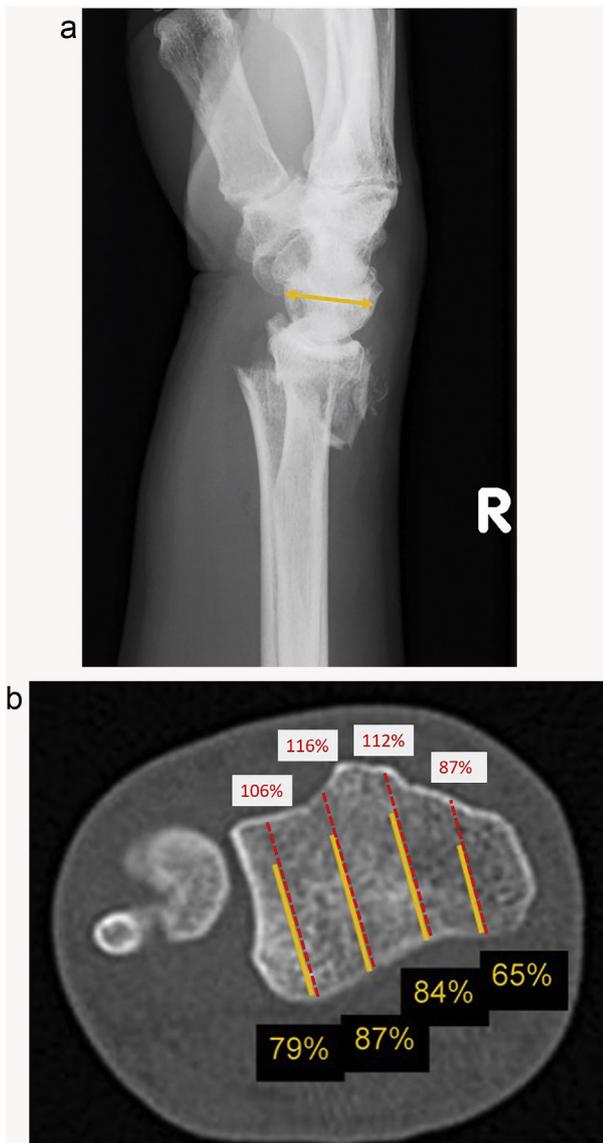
The lunate depth on a lateral X-ray view (A). Percentages of the full distal radial depth (red dotted line) reported by Ljungquist et al., and percentages of the 75% distal radial depth (yellow solid line), compared with the lunate depth (B).
